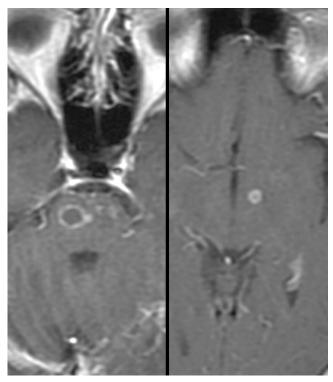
Contrast enhanced axial T1-weighted MR images show marked ring enhancement of the lesion located in the pons and in the left cerebral peduncule.
